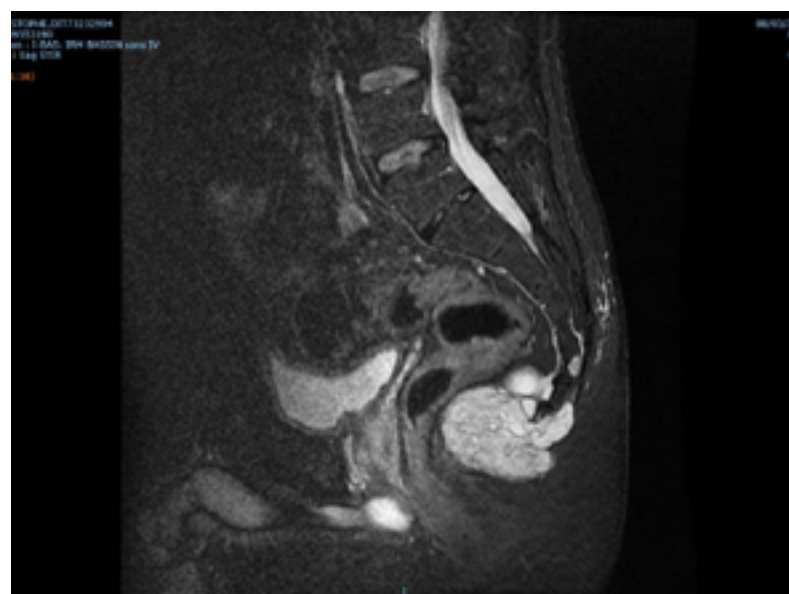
T2-weighted MRI showing hyperintensity of coccyx chodorma with an anterior development toward the rectum
